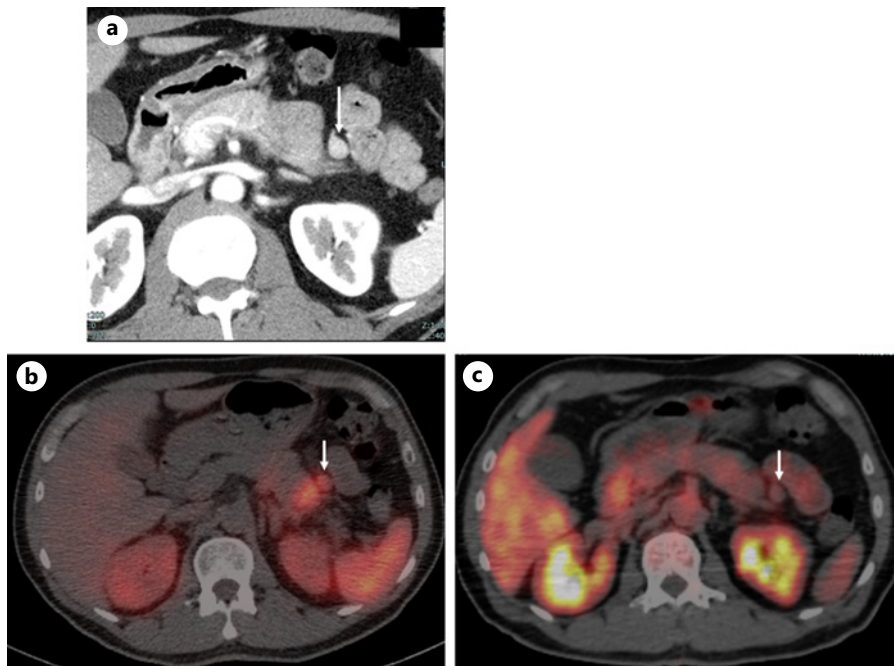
FDG-PET/CT and SRS with SPECT/CT findings of #18 lymph node metastasis. a Contrast-enhanced CT showed a significantly enlarged #18 node measuring 10 × 12 mm (arrow), suggesting nodal metastasis. b SRS with SPECT/CT showed abnormal uptake in the #18 node (arrow), suggesting nodal metastasis. c FDG-PET/CT showed no FDG uptake in the #18 node (arrow).
